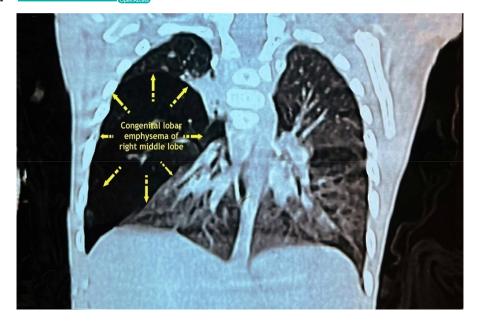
Preoperative coronal reformatted high-resolution computed tomography scan shows congenital lobar emphysema of the right middle lobe.
